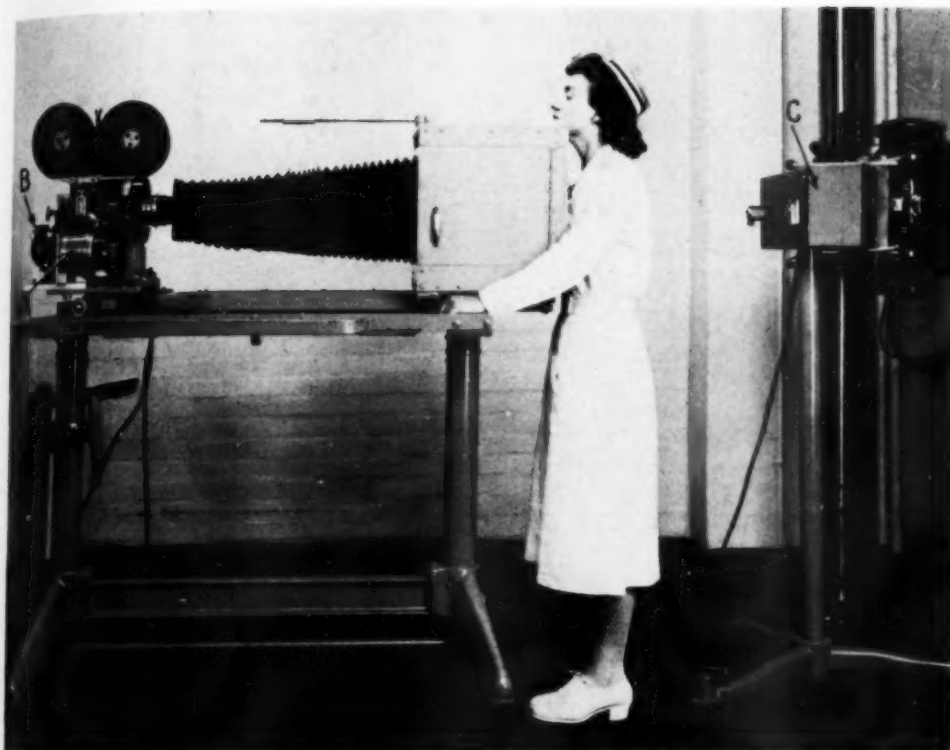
Thirty-five-millimeter cinefluorographic unit. Camera at left with camera drive motor (B) and repeater motor (A). Lead shutter mechanism (C) between x-ray tube and subject.
